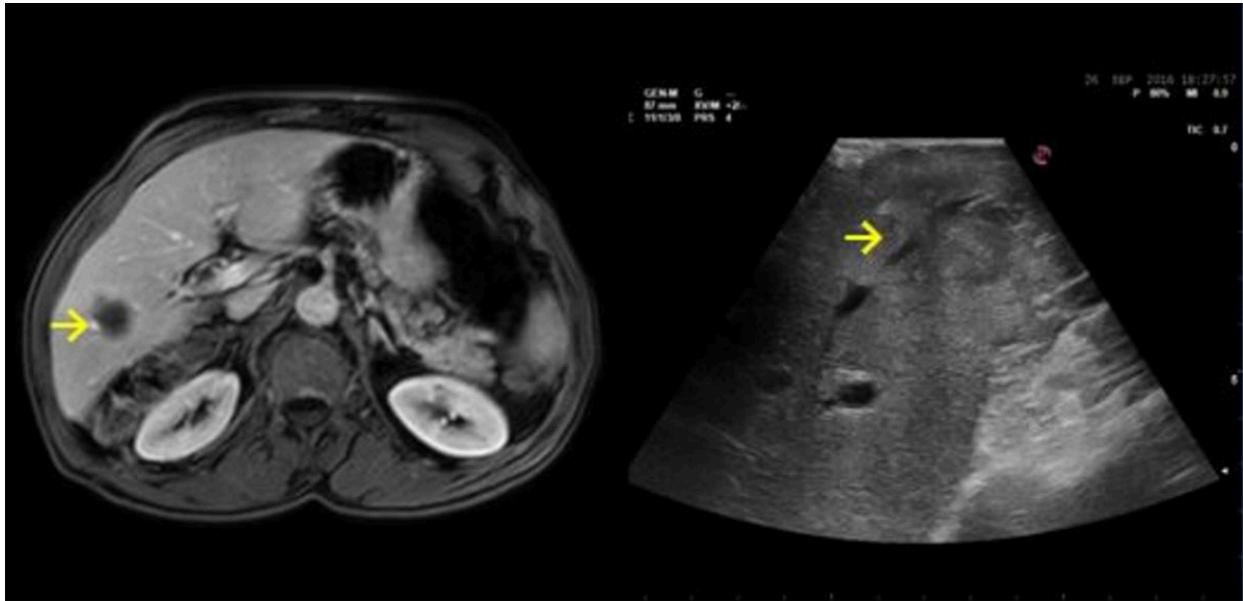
Colic liver metastasis of segment 7 in contact with the right hepatic vein (yellow arrow) on MRI. This vein has proved to be invaded by the tumor in IOUS examination.
